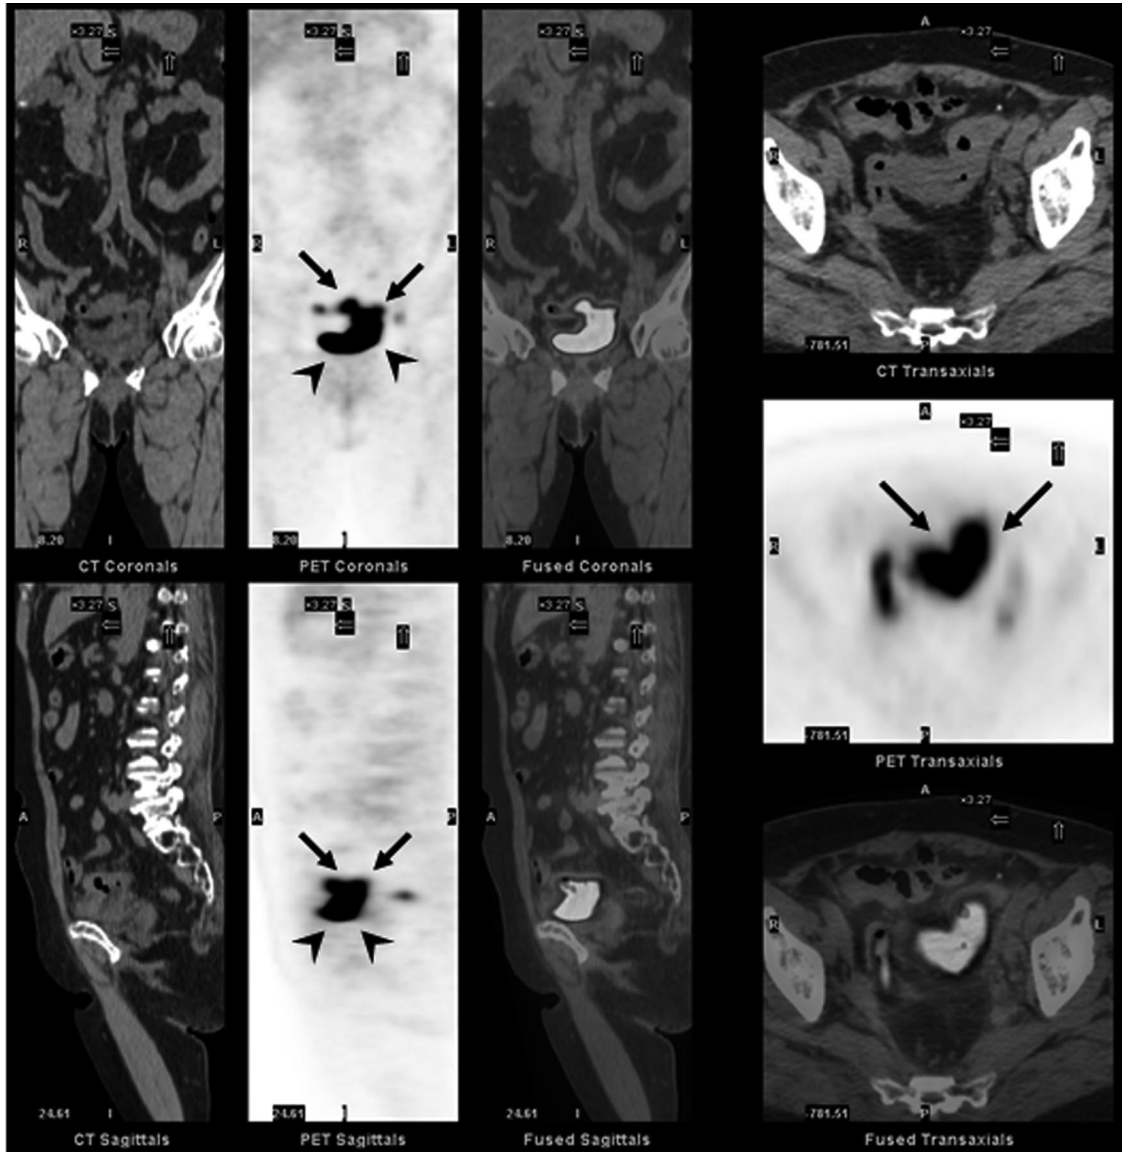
Under the impression of recurrent cervical cancer, FDG PET/CT was performed for whole-body cancer work-up.¹ The transaxial, coronal, and sagittal views of CT, PET, and fused PET/CT images revealed intense accumulation of FDG activity in the sigmoid colon (arrows), which was seen downwardly connected with the activity in the urinary bladder on PET images (arrow heads). The measured 1-hour SUVmax in sigmoid colon was unusually high as 72.42, which was very close to that measured in the urinary bladder (SUVmax: 87.74) and was considered to be contaminated by urine FDG activity via a fistula.² In addition, there was irregular wall thickening for sigmoid colon and urinary bladder, with a hypodensity tract communicating both organs on the coregistered CT images, compatible with tumor invasion involving both sigmoid colon and urinary bladder with a fistula formation (best seen on coronal views). The following cystoscopy revealed mass lesions involving superior walls of bladder. Combining the typical symptoms and the findings of PET/CT, it was concluded that recurrent cervical cancer involving both urinary bladder and sigmoid colon resulted in colovesical fistula (CVF). CVF is an abnormal connection between the bladder and large intestine, usually sigmoid colon. The most common underlying etiology was diverticular disease, followed by colon cancer, Crohn's disease, bladder cancer, radiotherapy, and trauma.³⁻⁵ The orders of presented symptoms were pneumaturia, urinary tract infection, dysuria, fecaluria, and hematuria. CT was the modality of choice to establish the diagnosis of CVF, and colofibrosopy was followed to rule out malignancy as a cause of CVF. Barium enema and cystography were also suggested to be useful, whereas, cystoscopy and intravenous pyelogram were nondiagnostic.⁶ The experience of FDG PET/CT, an integrated metabolic and anatomic imaging modality, on CVF has not been reported before. As presented in our case, the physiologic urine excretion of FDG, as well as other renal excreting agents, like Tc-99m MDP and Tc-99m DTPA, makes it a very good contrast agent of urinary tracts to visualize CVF.⁷⁻⁹ FDG PET/CT is promising in detecting CVF.
